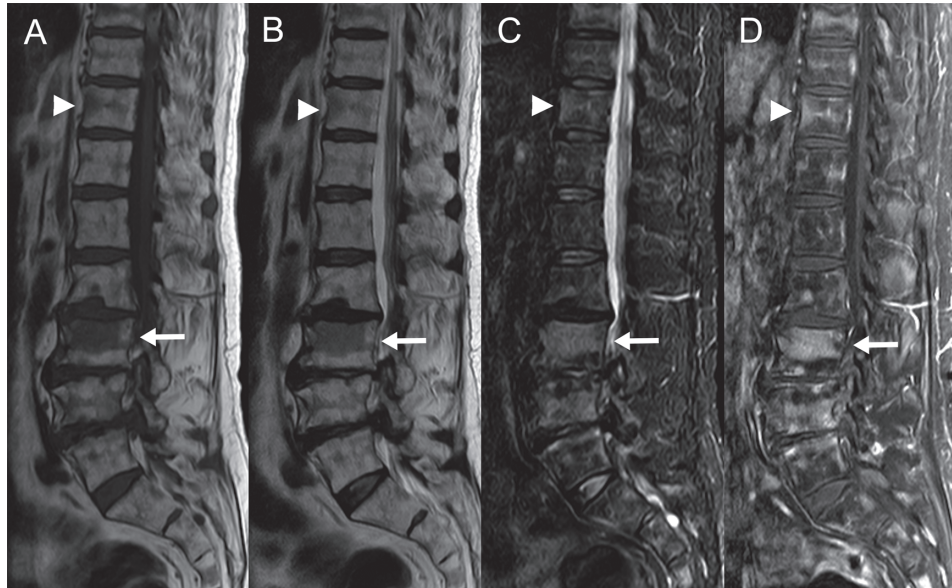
Magnetic resonance imaging (MRI) findings. Sagittal T1-weighted (A) and T2-weighted (B) spin-echo MR images of the thoracolumbar spine showing a focal hypointense lesion in the L3 vertebral body (arrows). Sagittal short tau inversion recovery (STIR) image (C) and fat-saturated T1-weighted image after gadolinium administration (D) showing a hyperintense lesion with contrast enhancement in the L3 vertebral body (arrows). Patchy focal bone lesions with similar signal features to the L3 bone lesion were detected in the other lumbar vertebrae (arrowheads).
